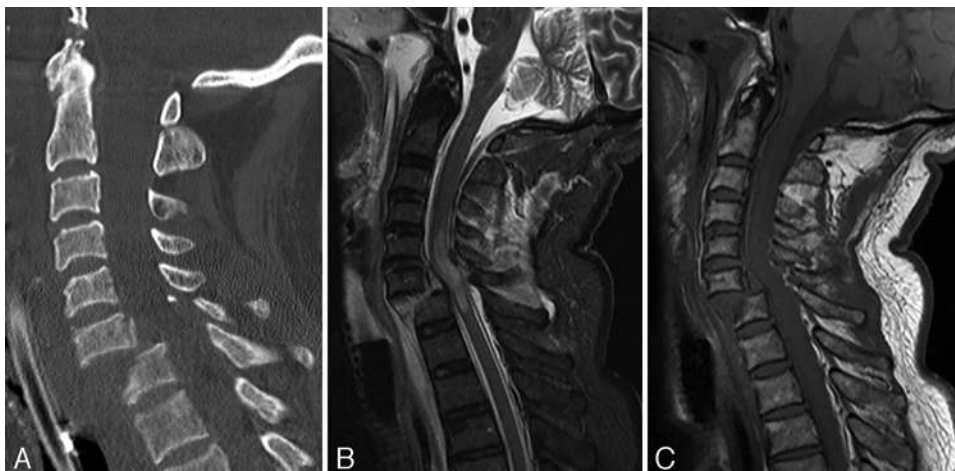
Representative sagittal CT (A), sagittal STIR (B), and T1 (C) MR images at 3 T of an ASIA grade A SCI in the setting of a 3-column injury with traumatic anterolisthesis of C6 on C7 due to an acute C6/C7 intervertebral disc injury, significant ligamentous injuries (anterior longitudinal ligament, posterior longitudinal ligament, and ligamentum flavum tears), fracture of the C7 anterosuperior endplate, multiple posterior element fractures (not all shown), and the associated cervical cord injury extending from C4 to C7/T1.
